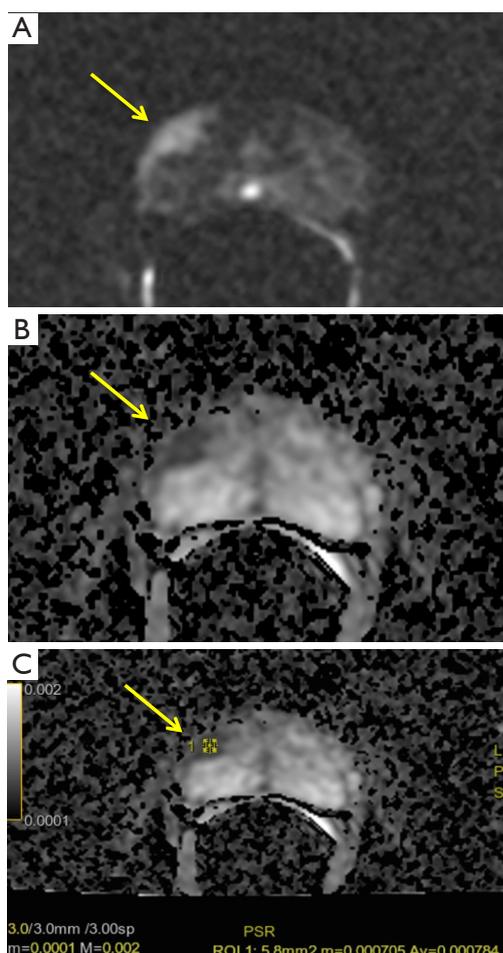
DWI (A) and ADC map (B) in patient with GS 7 prostate cancer (yellow arrow). ADC analysis (*) (C) show a mean value of 0.784×10^{-3} , consistent with the Gleason cancer grading. DWI, diffusion weighted imaging; ADC, apparent diffusion coefficient.
